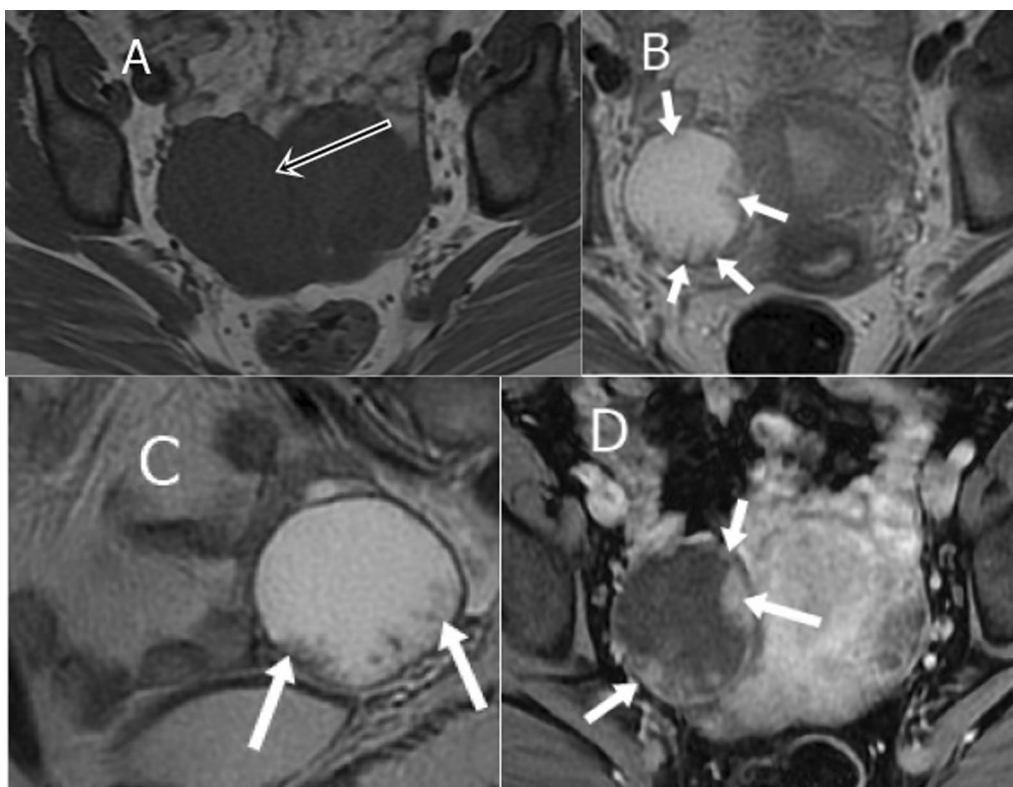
O-RADS MRI score 4 in a 29-year-old female with pelvic pain A Axial T1WI, B, C axial, sagittal T2WI: Right adnexal cystic lesion (black arrow) shows few small mural nodules (white arrows) of low T1 and intermediate to high T2 SI. D Coronal T1 post-contrast image shows relatively thick marginal contrast enhancement and enhancement of the mural nodules (white arrows) [with enhancement pattern categorized as intermediate risk]. This was pathologically proven borderline serous ovarian tumor with intact capsule
